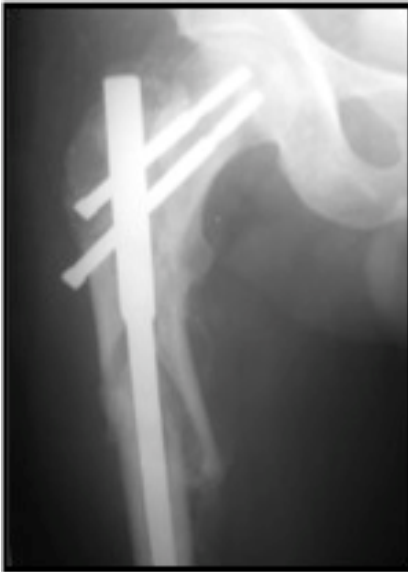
6 weeks follow up X-Ray
